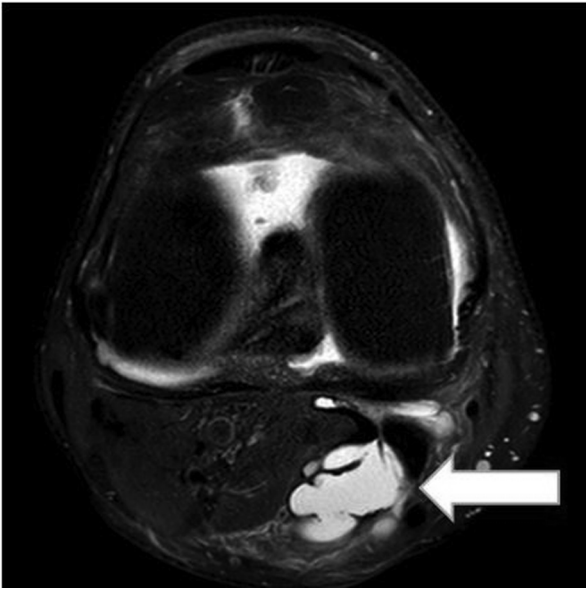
Axial magnetic resonance imaging scan of the right knee. Popliteal cyst is indicated by the white arrow.
